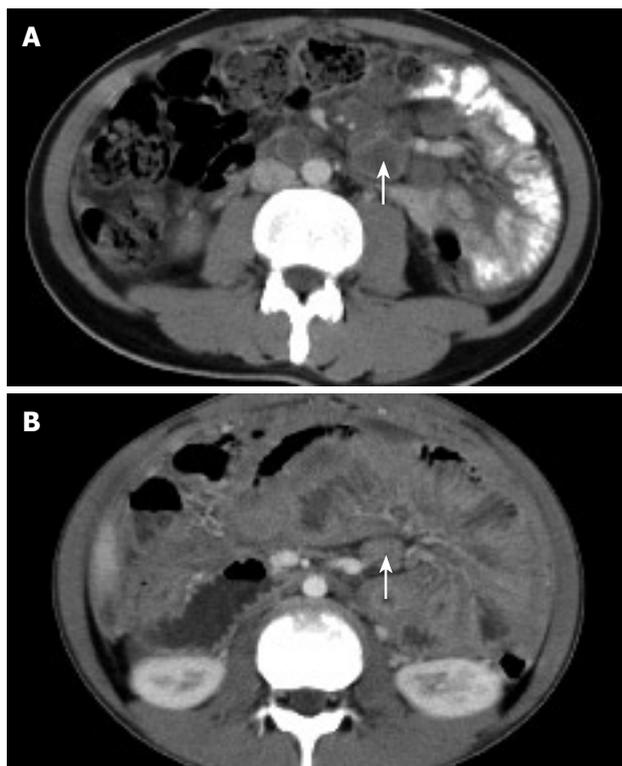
Contrast enhanced CT scan for a 25-year-old man with mesenteric TL showing enlarged lymph nodes in the body and root of SBM with peripheral enhancement (arrow) (A) and in the body of SBM with homogeneous enhancement (arrow) (B). The SBM was contracted and the wall of the small bowel was thickened.
